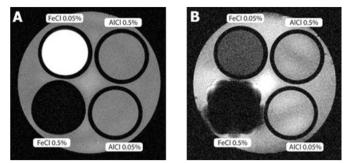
T1-weighted image (TE 3.3ms/TR 100ms), Figure-1B, T2-weighted image (TE 20ms/TR 1000ms). The 0.05%-FeCl₃ solution appears hyperintense on the T1-weighted and hypo-intense on the T2-weighted images. 0.5%-FeCl₃ is hypo-intense on both images, with susceptibility artifacts. AlCl₃ shows similar signal intensity as the surrounding water and no artifacts.
